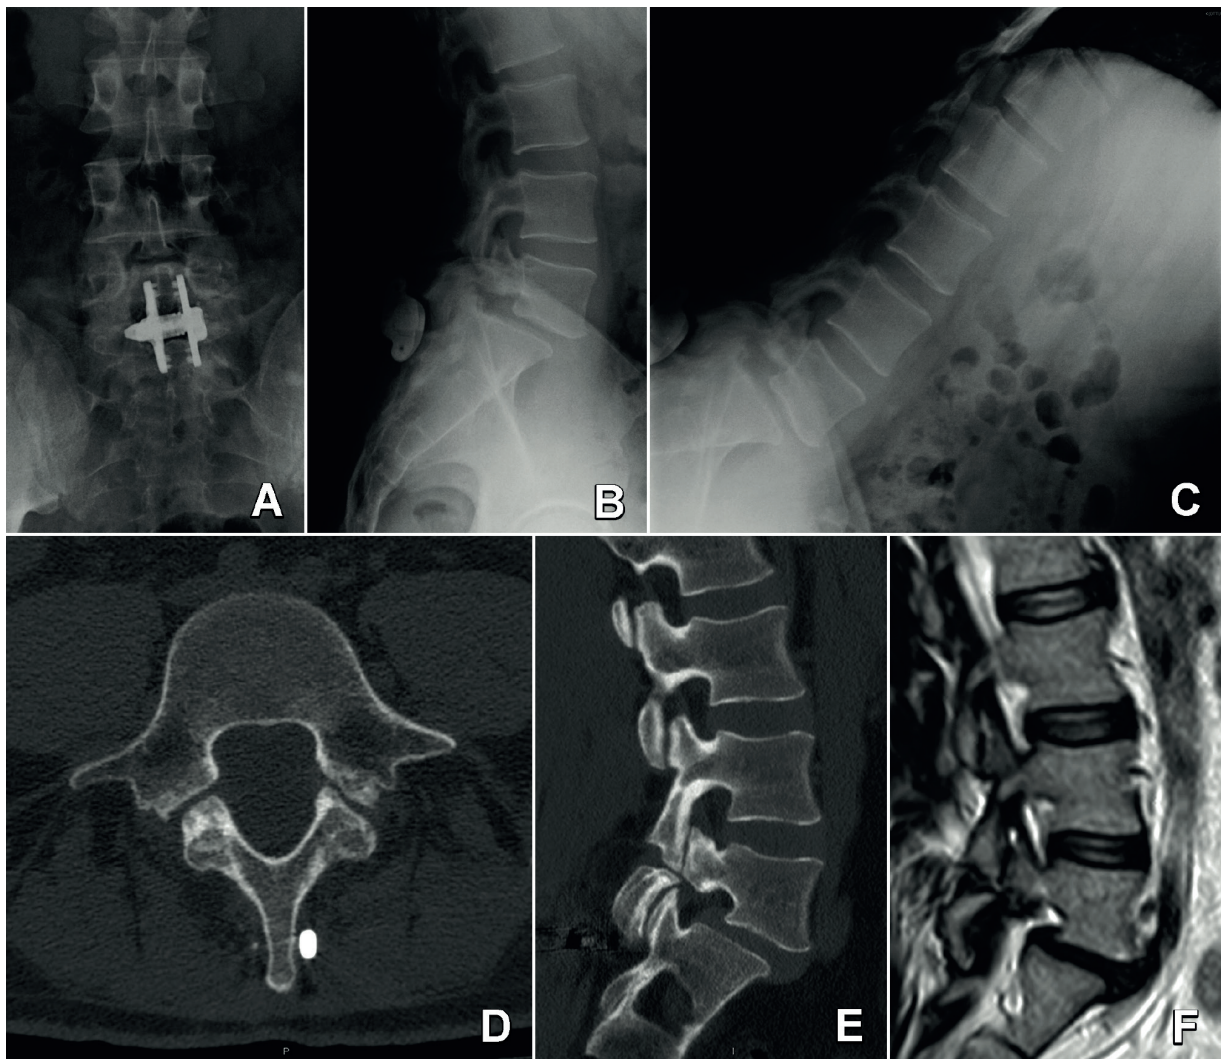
Radiological assessment performed after the treatment of IPD placement, showing that isthmic spondylolisthesis is still present. Anteroposterior (A), lateral (B) and flexion standing (C) radiographs; axial (D) and sagittal (E) CT scan; sagittal MRI (F), showing the degeneration of the L5-S1 intervertebral disc.
